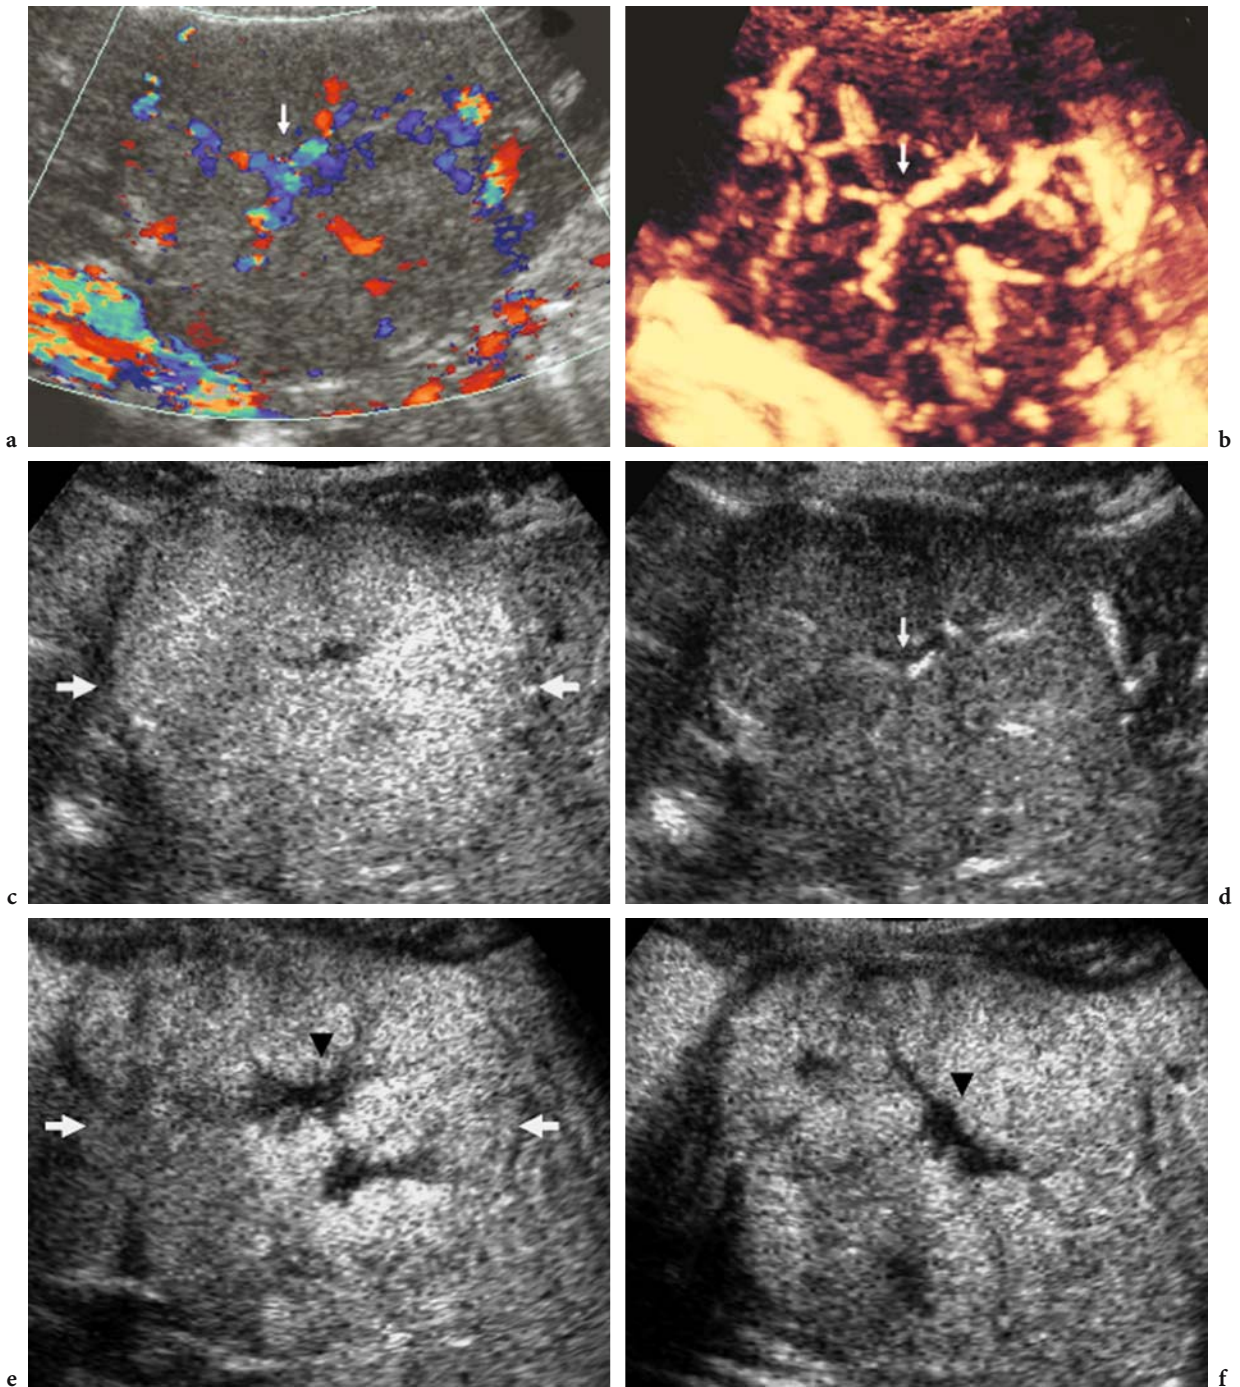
Focal nodular hyperplasia: spoke-wheel shaped contrast enhancement. a, b Baseline color (a) and power (b) Doppler. The central spoke-wheel shaped pattern (*arrow*) is identified, with a central vessel branching toward the periphery. c-f Contrast-enhanced US. Contrast-specific mode: Pulse Inversion Mode (Philips-ATL, WA, USA) after air-filled microbubble injection with high acoustic power insonation and production of four frames after each insonation. Diffuse homogeneous (*arrows*) contrast enhancement is evident during the arterial phase in the first frame of the train (c), while intratumoral vessels with a spoke-wheel shaped appearance (*arrow*) are identified in the second frame of the train (d). Diffuse contrast enhancement (*arrows*) persists in the late phase (e, f), sparing a central hypoechoic region (*black arrowhead*) that corresponds to the central scar.
